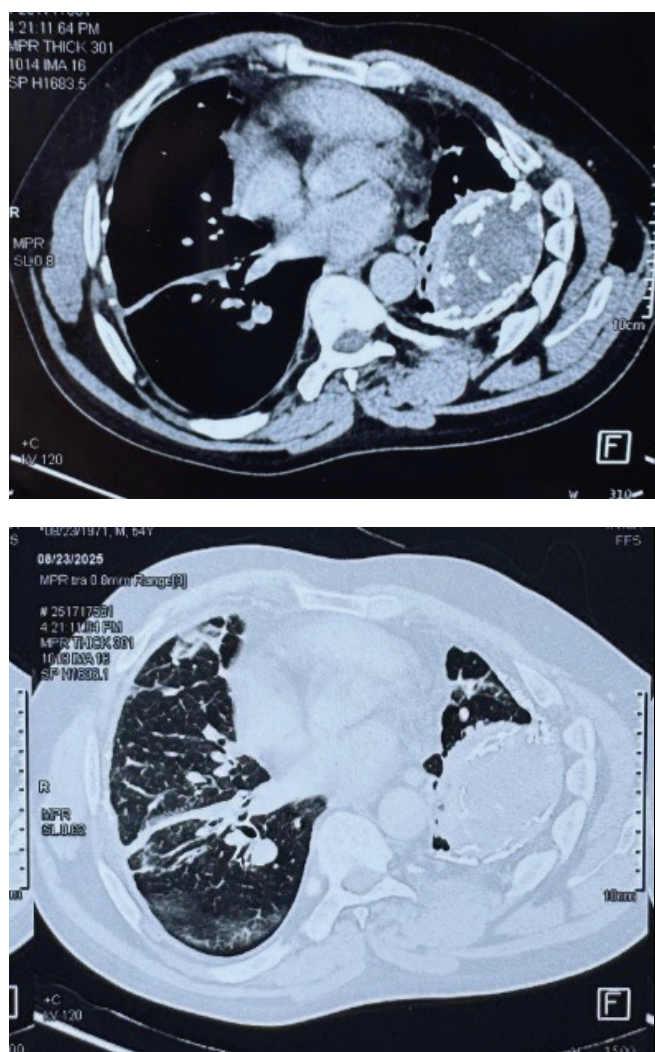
Axial contrast-enhanced CT scan demonstrating long-standing untreated empyema thoracis with a markedly thickened and calcified pleural peel adherent to the left lung, causing fibrothorax.
